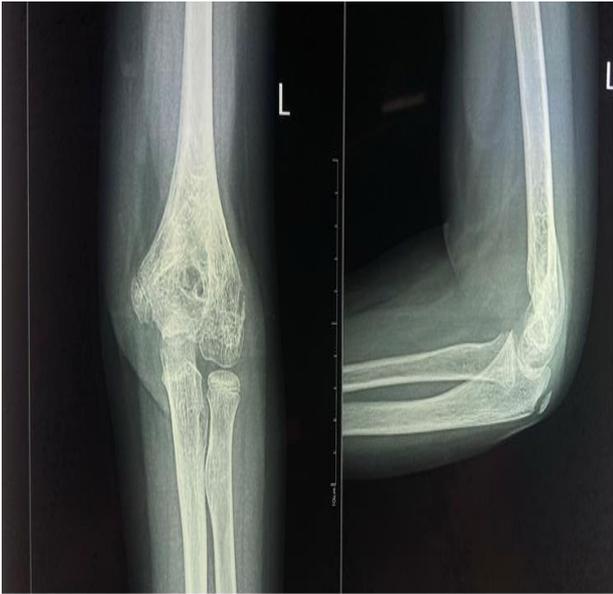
One year post op X-ray.
